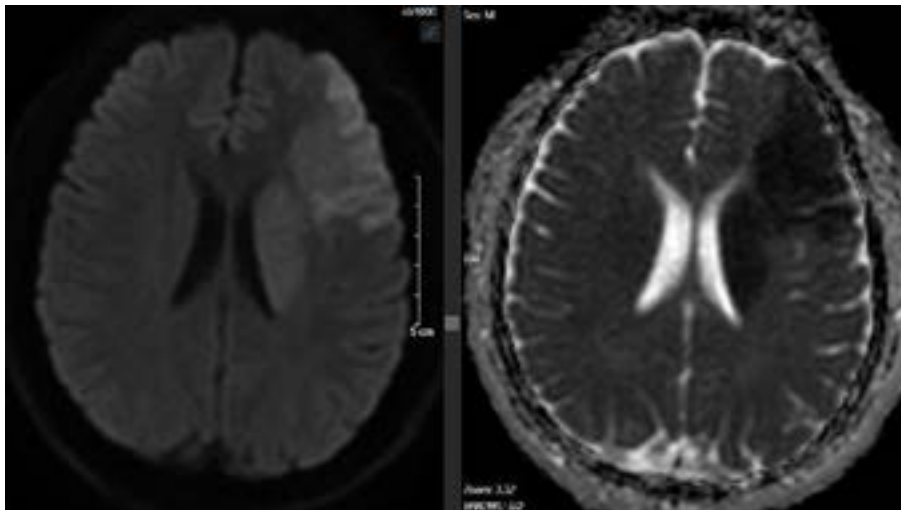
DWI/ADC sequence: Acute infarction in the left frontal lobe, basal ganglia, and insula
